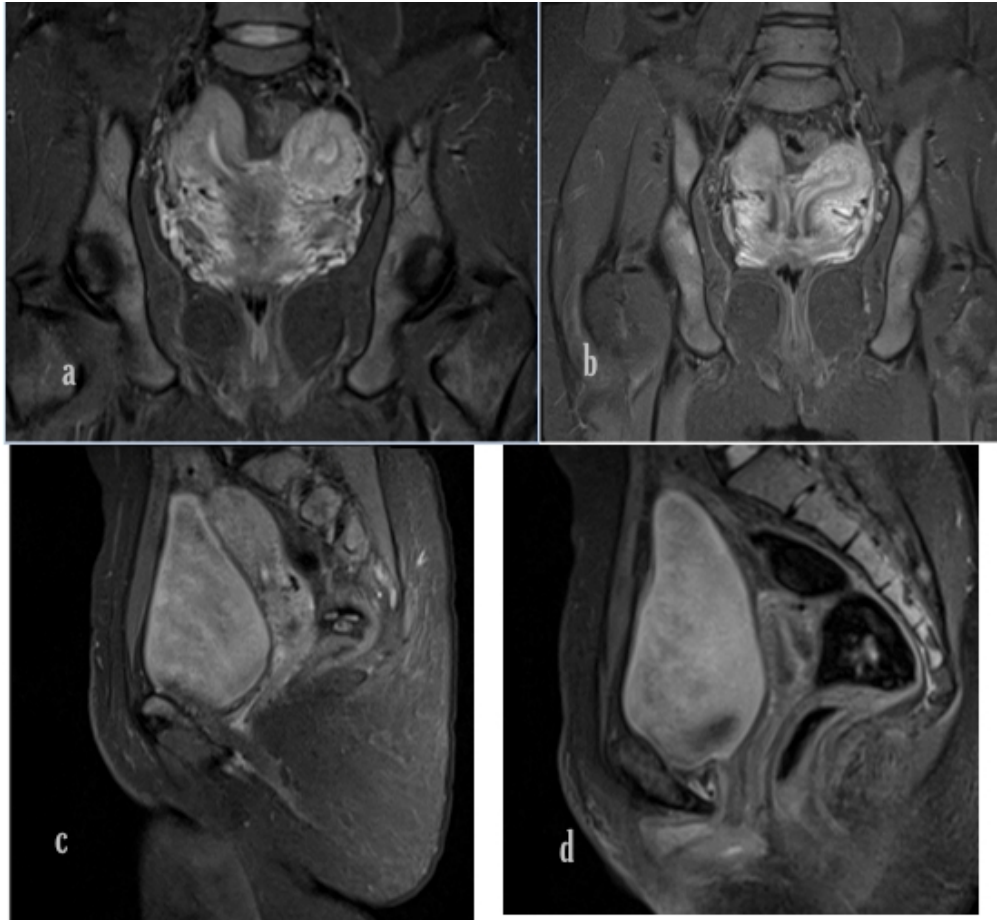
MRI of 23 years old female who came with pain in abdomen and bleeding per vagina. Coronal T2WI (a and b) and Sagittal T2WI (c and d) show large right uterus and small left uterus ,two separate uterine bodies and cervices with two separate endometria. Thin vaginal septum was also seen (b).
